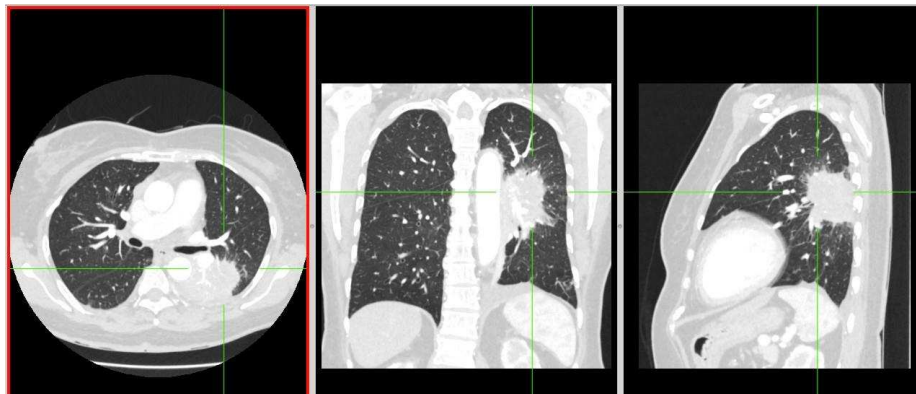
A 36-year-old woman with pulmonary LH on a chest CT scan with contrast, showing a mass in the lung with spiculated edges
